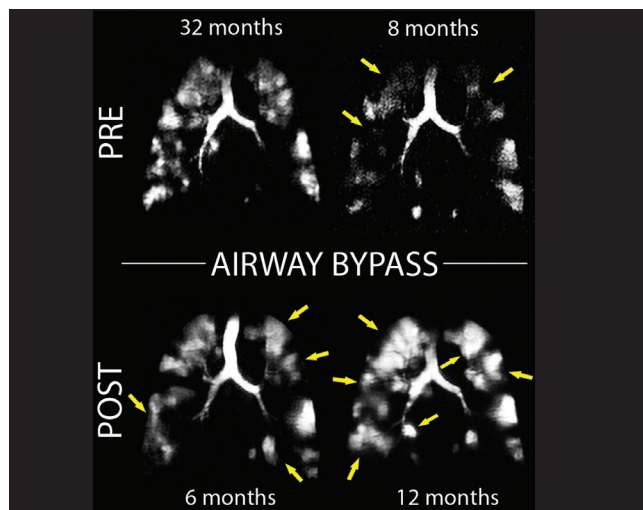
³He magnetic resonance (MR) ventilation image of a Global initiative for chronic Obstructive Lung Disease (GOLD) stage III chronic obstructive pulmonary disease exsmoker 32 months before airway bypass (AB) (top left panel): forced expiratory volume in 1 s (FEV₁) = 32% predicted, forced vital capacity (FVC) = 66% predicted, and eight months before AB (top right panel), FEV₁ = 23% predicted, FVC = 49% predicted. Heterogeneous ³He signal intensity and large ventilation defects are visualized in both scans, with ³He MR ventilated volume decreased by 3.8 L during this two-year time period. In February 2009, two stents were inserted into the left upper lung and two into the right lower lung, with ³He MRI acquired six months post-AB (lower left panel): FEV₁ = 33% predicted, FVC = 76% predicted; and 12 months post-AB (lower right panel), FEV₁ = 35% predicted, FVC = 81% predicted. Improved gas distribution post-AB is suggested with new regions of ³He ventilation and increased ³He signal intensity, and ventilated volume at both time points post-AB.
